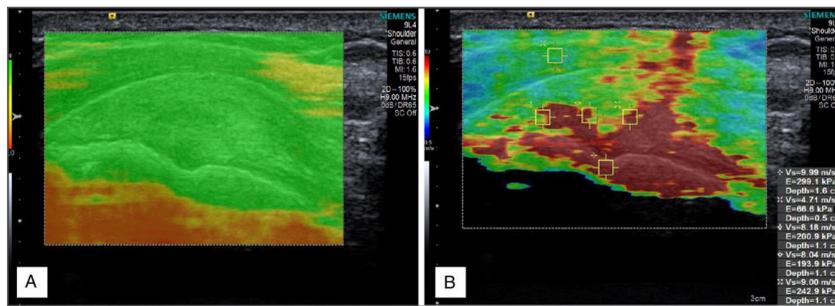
Standard B-mode ultrasound (A) compared with shear-wave elastography of the supraspinatus tendon (B).
